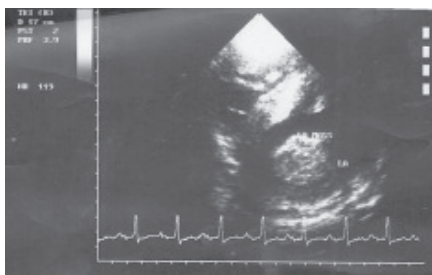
2-D Echocardiogram of a 40-year old Nigerian with rheumatic mitral valve disease and a giant clot in the left atrium.
